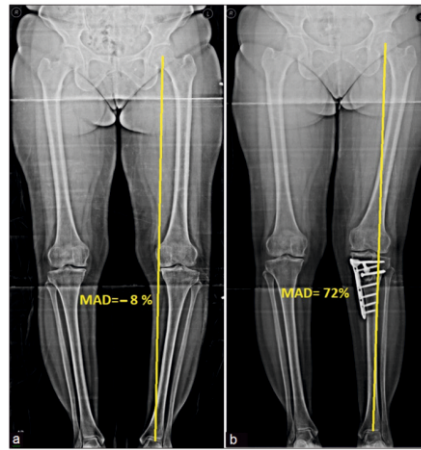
(a) Preoperative full-length X-ray of a 62-year-old female with left MCOA, MAD is at -8%; (b) postoperative full-length X-ray after FDCO showing left lower limb MAD is at 72%. MCOA: Medial compartment osteoarthritis, MAD: mechanical axis deviation, FDCO: Focal dome condylar osteotomy
